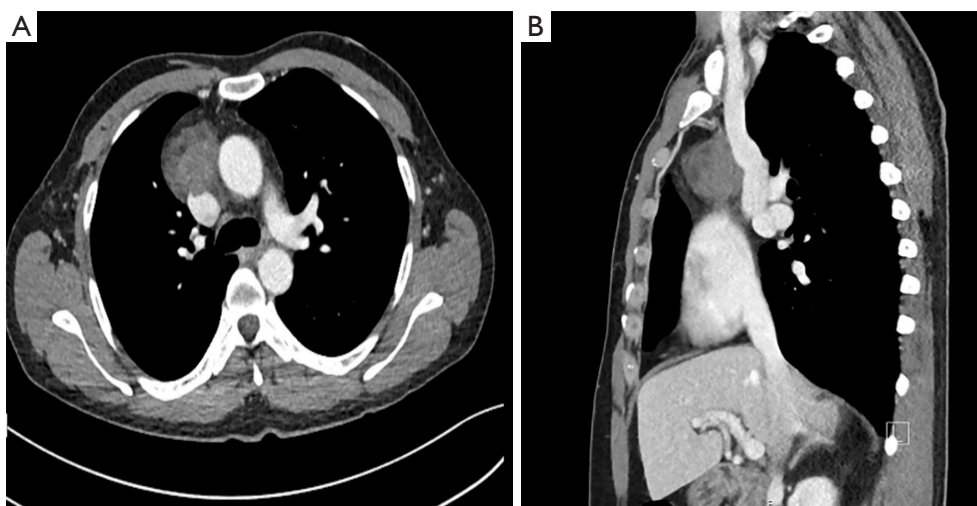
CT showing an attenuating mass within the anterior mediastinum intimately related to the anterior aspect of the superior vena cava. (A) Axial view; (B) sagittal view. CT, computed tomography.
